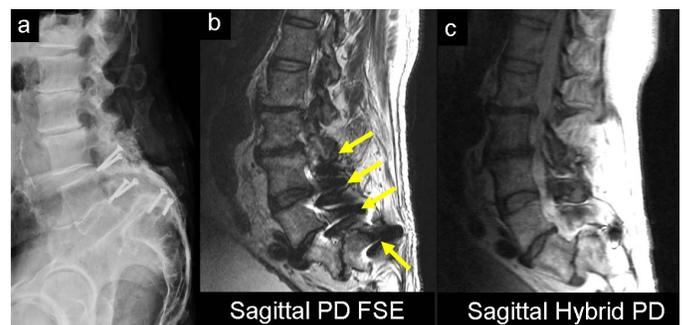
(a) Lateral xray and (b, c) Sagittal MR images in a 73 year old man with 3-level spinal fusion for grade III isthmic spondylolisthesis of L5 on S1 presenting with low back pain for 1 week. Prominent through plane artifact is seen on PD FSE (arrows). No significant neural compromise was seen and the patient was treated conservatively.
